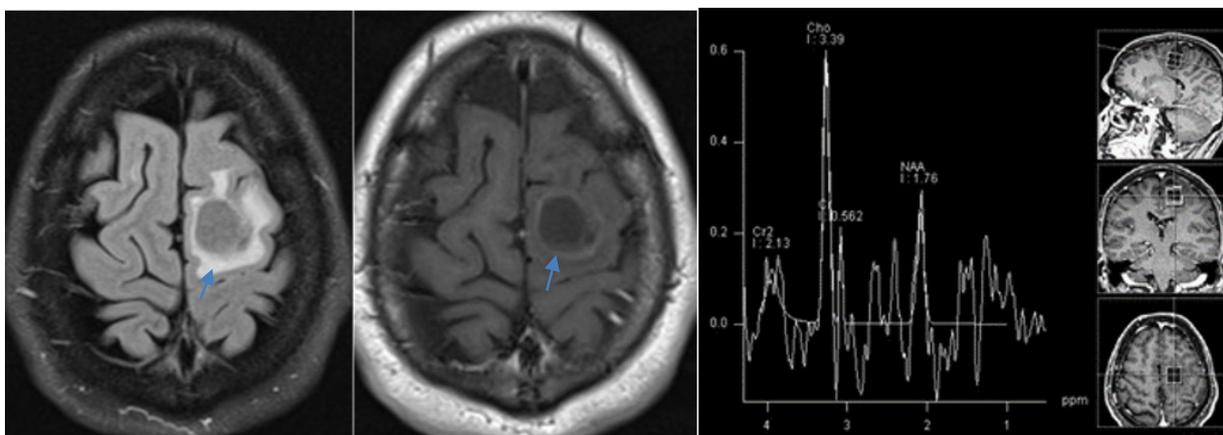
FLAIR- and TI- contrast axial images showing lesion in left frontal centrum semi ovale measuring 2 cm x 2.5 x 4 cm, hypointense in FLAIR surrounded by perifocal edema, mass effect and faint rim enhancement. MRS showing elevated lactate and choline peaks while NAA peak is reduced.
